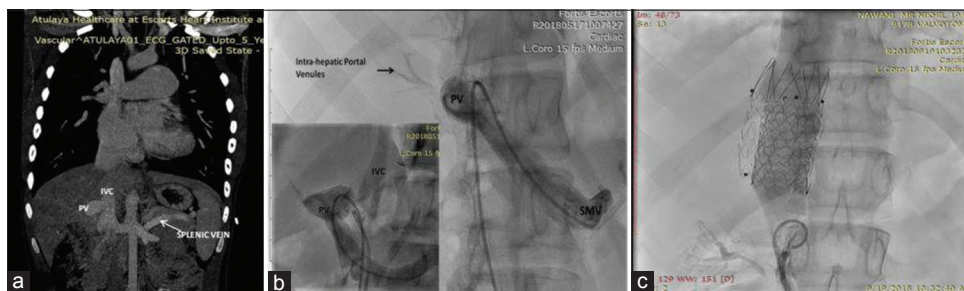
(a) Contrast-enhanced computed tomography abdomen coronal images showing Type 2 Abernethy malformation where the portal vein is seen draining into inferior vena cava. (b) Shows still image from intra-cardiac catheterization, wherein selective injection into the superior mesenteric vein shows filling of the portal vein, and then the portal vein is draining into the inferior vena cava. (c) Shows the abnormal connection being closed with the help of a covered stent
